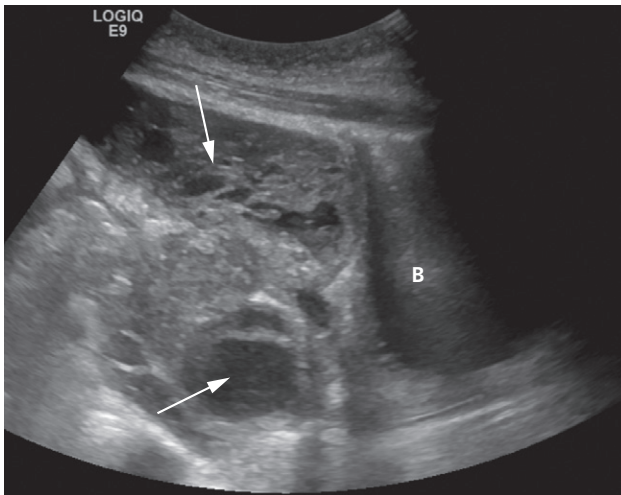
Pelvic abscess. Ultrasound scan showing a highly complex cystic and solid hypoechoic mass with multiple locules (arrows) behind the bladder (B).
